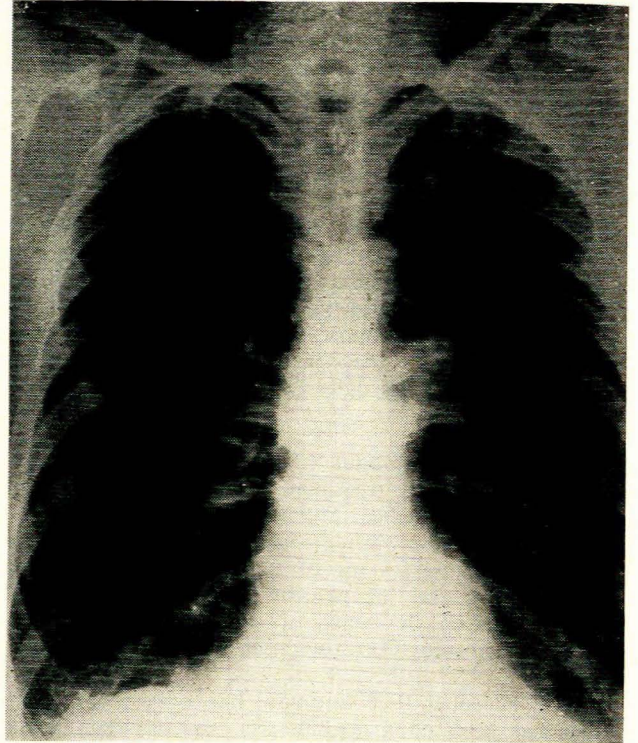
Chest X-ray of case 1 taken in 1967.
